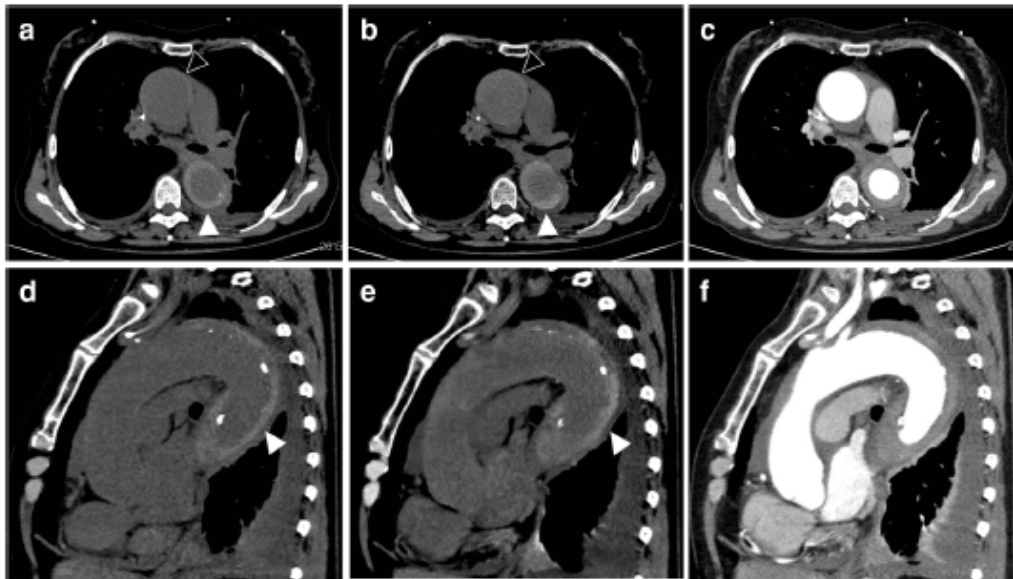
CT scan of a 64-year-old patient diagnosed with aortic IMH (full arrowheads) on the TNC (a, d) and VNC (b, e) images, which was hardly visible at the level of the ascending aorta (empty arrowheads), especially
